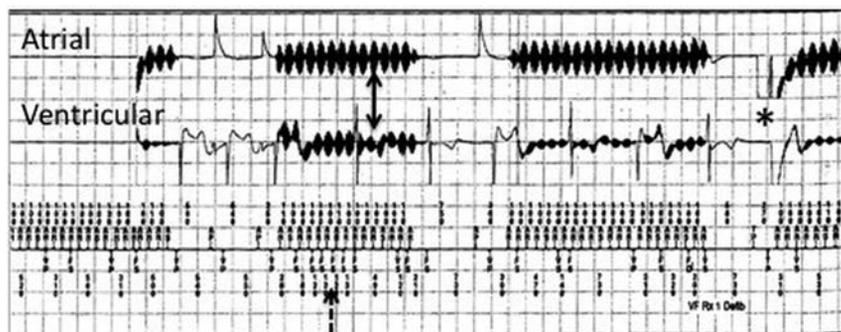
Risk categorization: inappropriate device sensing during MR imaging. Intracardiac electrograms from a patient with a dual-chamber ICD. Electromagnetic interference is seen on both atrial and ventricular channels (solid arrows), resulting in oversensing (dashed arrow) and an inappropriate ICD shock (asterisk).
